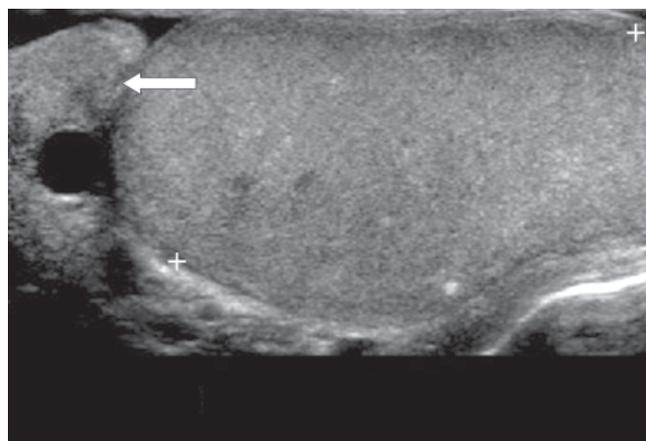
Ultrasonographic representation of the didymis (comprised between the two crosses) and of the epididymis (arrow).
